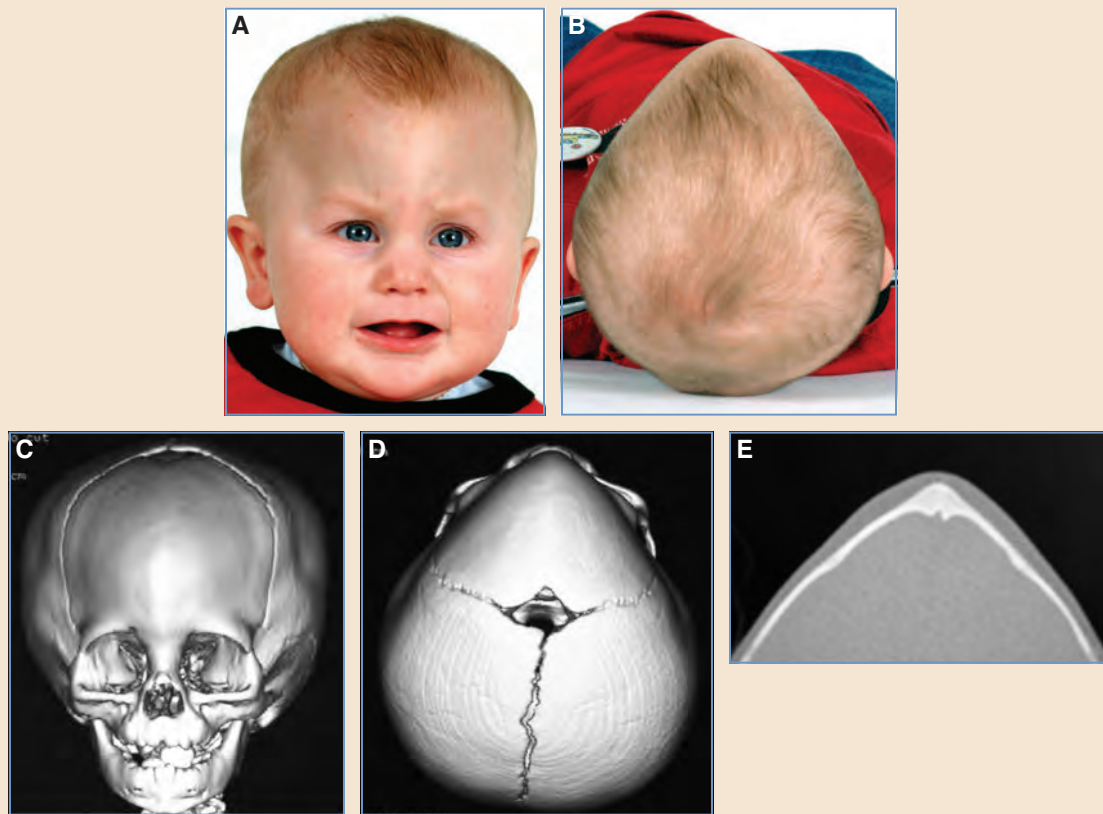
This 8-month-old male has metopic synostosis. A and B, Hypotelorism and a midline forehead prominence were evident clinically. C-E, CT revealed the additional findings of a trapezoidal orbital configuration, trigonocephaly with posterior cranial vault compensatory expansion, and a small midline notch on the endocranial surface, known as an *omega sign*, often seen in metopic synostosis.
